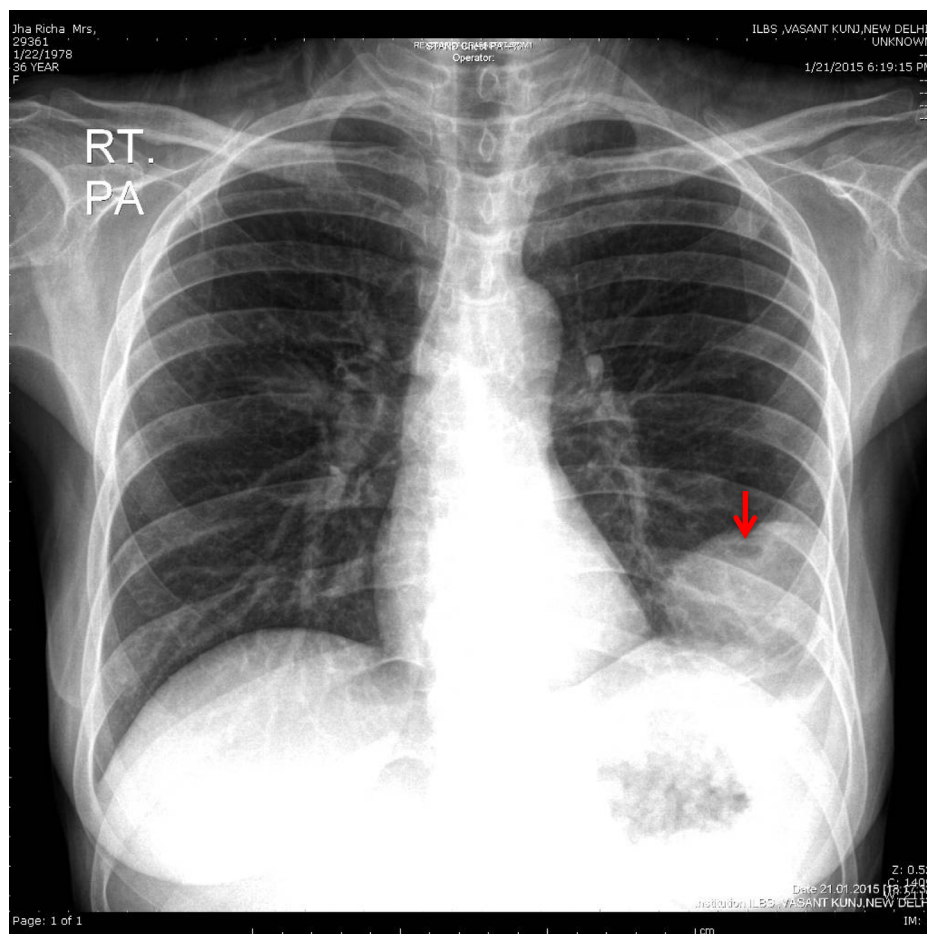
X-ray chest showing pleural based well defined, homogenous opacity with air fluid level within (arrow) indicative of loculated empyema with underlying lung abscess.
